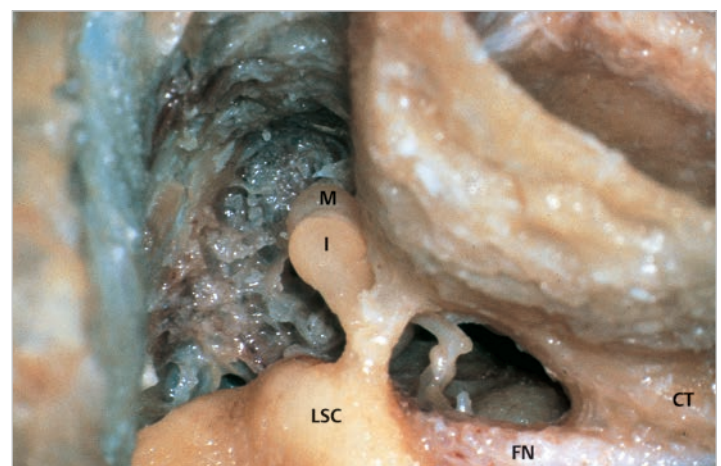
Canal wall up technique in another temporal bone is shown. The posterior epitympanotomy and posterior tympanotomy are completed, and the medial wall of the attic anterior to the semicircular canals is drilled. The ossicular chain and the area of the oval window are seen. CT, chorda tympani; FN, facial nerve; I, incus; LSC, lateral semicircular canal; M, malleus.
